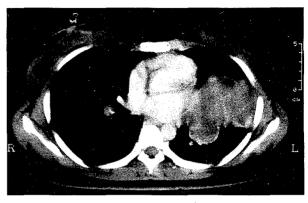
Chest CT scan showing a soft tissue mass in the lingual division of the upper left lobe bronchus with, occlusion of the bronchus, and no obvious enlarged lymph node within the mediastinum.
